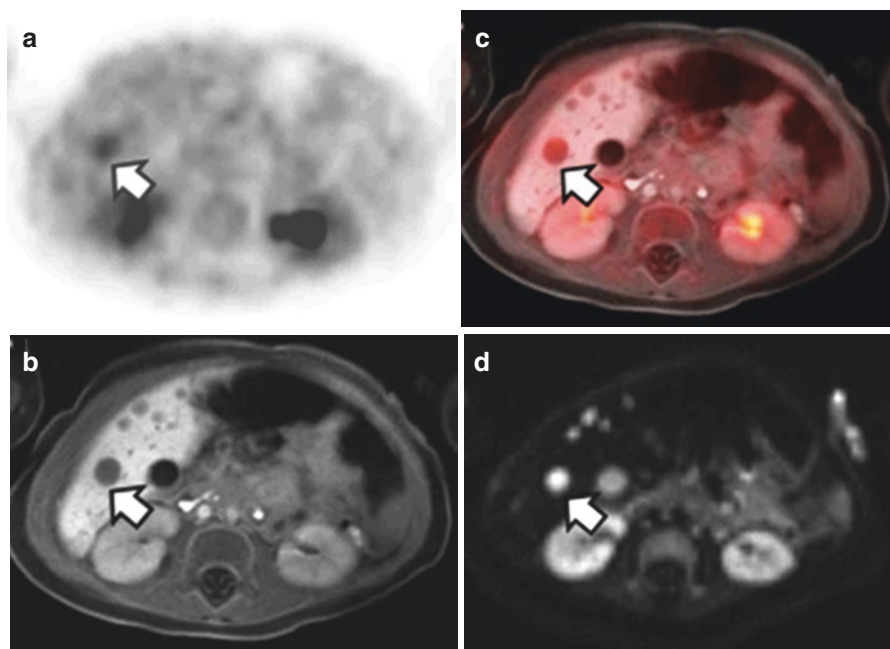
FDG-PET/MRI performed in a 4-month-old girl after recent resection of a right adrenal neuroblastoma. During surgery, liver metastases were discovered that were not well seen on preoperative CT. Whole body FDG PET/MRI shows hepatic lesions which are FDG-avid (a), hypoenhancing on the hepatobiliary phase MRI (b, f) and demonstrates restricted diffusion (d). Smaller lesions were not identified on FDG-PET but are well visualized on the hepatobiliary phase and DWI (d, h). (a, e) FDG-PET; (b, f) hepatobiliary phase MRI; (c, g) fused PET/MRI; (d, h) Diffusion weighted imaging (DWI); Maximum intensity projection (MIP) is also shown (i)
